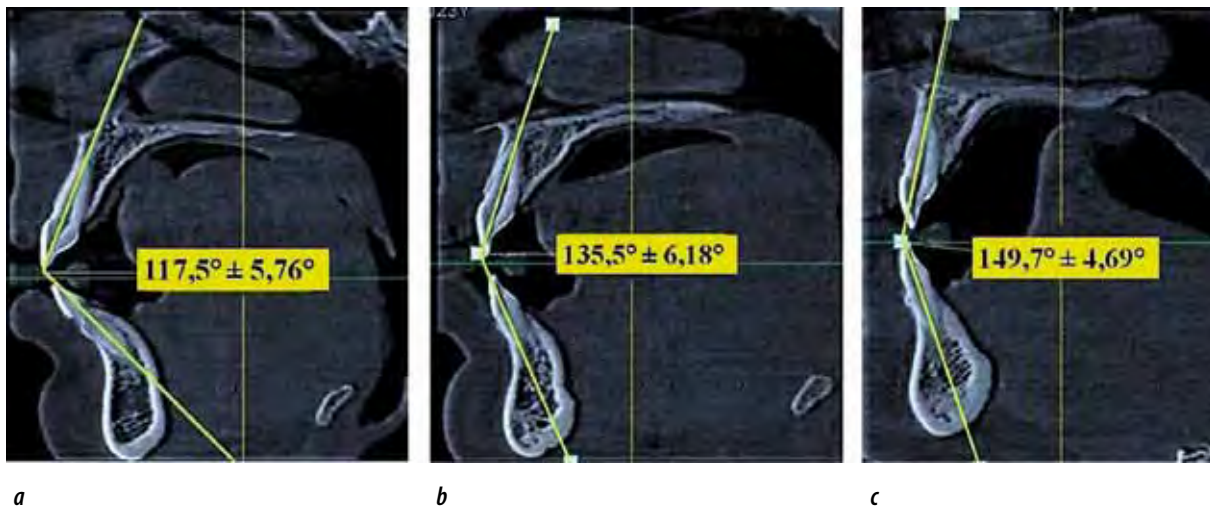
Images of the CBCT fragments with printed results of the incisal angle in case of dental arch protrusion (a), mesotrusion (b) and retrusion (c)
